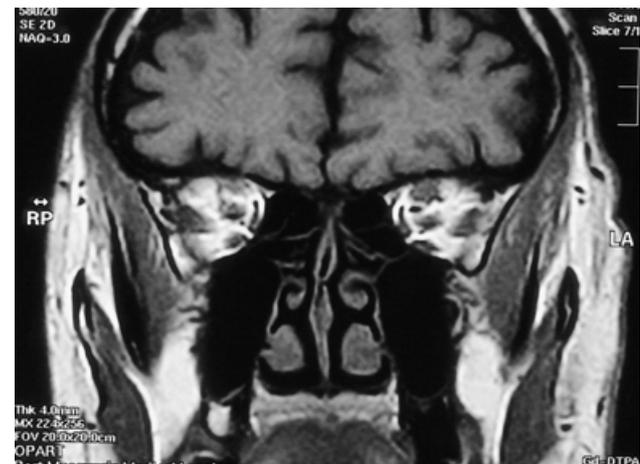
Magnetic resonance imaging scan highlighting thickening of the left supraorbital nerve secondary to perineural invasion.
